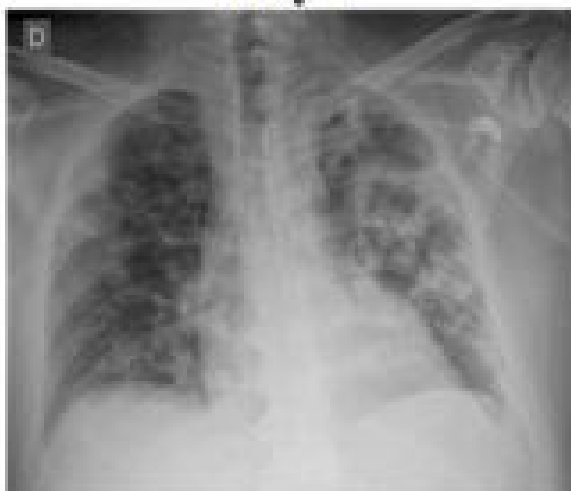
(c) Day 7 lung x-ray of COVID-2019 patient
